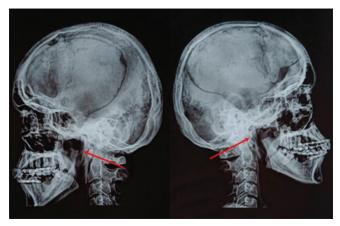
Red Arrows indicate bilateral eminectomy and condylectomy in post-operative radiographs
